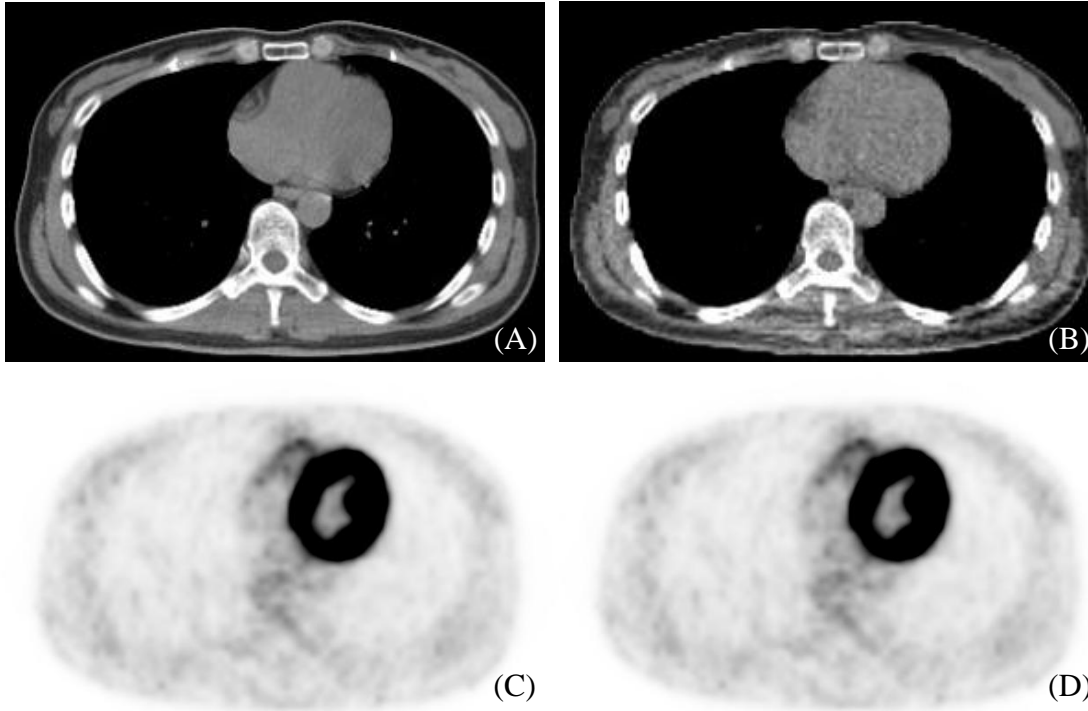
CT images for CT-based attenuation correction obtained using default scan parameters (A) and ULDCT (B). FDG-PET images with attenuation correction using CT images in (A) and (B) are shown in (C) and (D), respectively.
